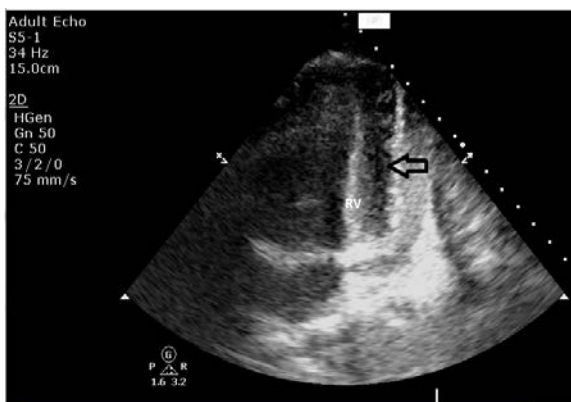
Transthoracic echocardiography showing significant pericardial effusion with RV compression suggestive of tamponade
